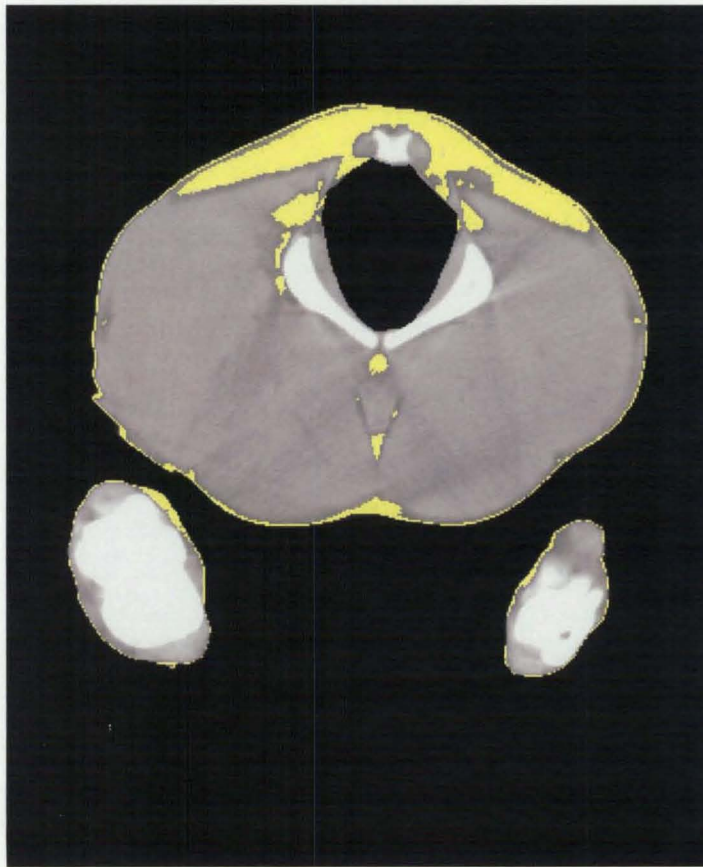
CT Image showing distribution of pixels in the greyscale range 35-120 corresponding with adipose. Highlighted pixels are 11% of total pixels
